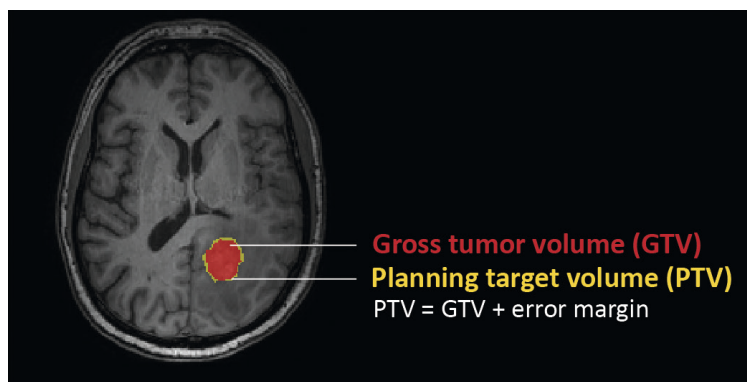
Treatment volumes for SRS overlaid on a T1-weighted MRI.
